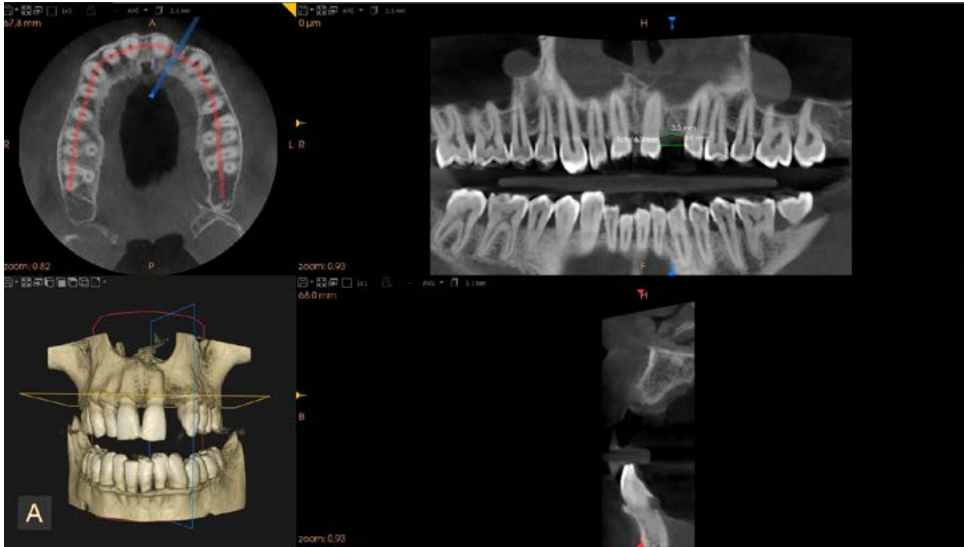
CBCT overall view one measured
